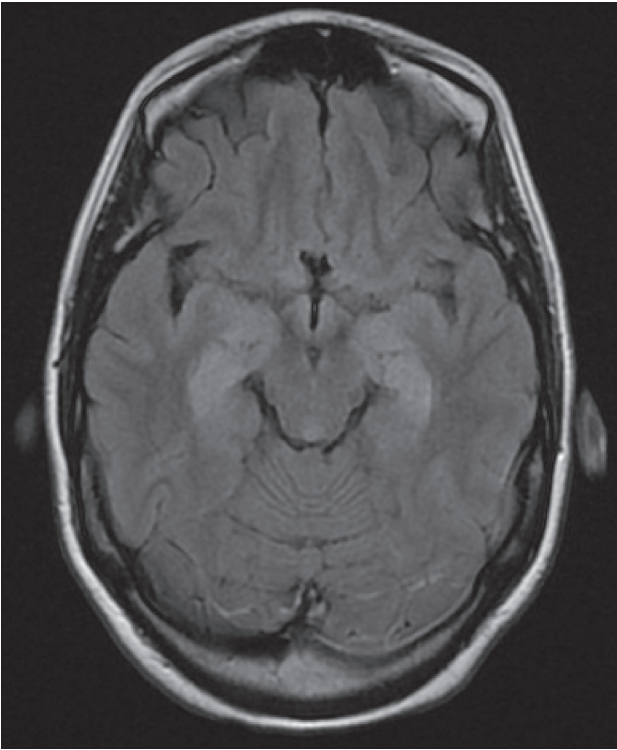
Axial FLAIR-weighted brain MRI showing a hyperintense signal in both medial temporal lobes.
